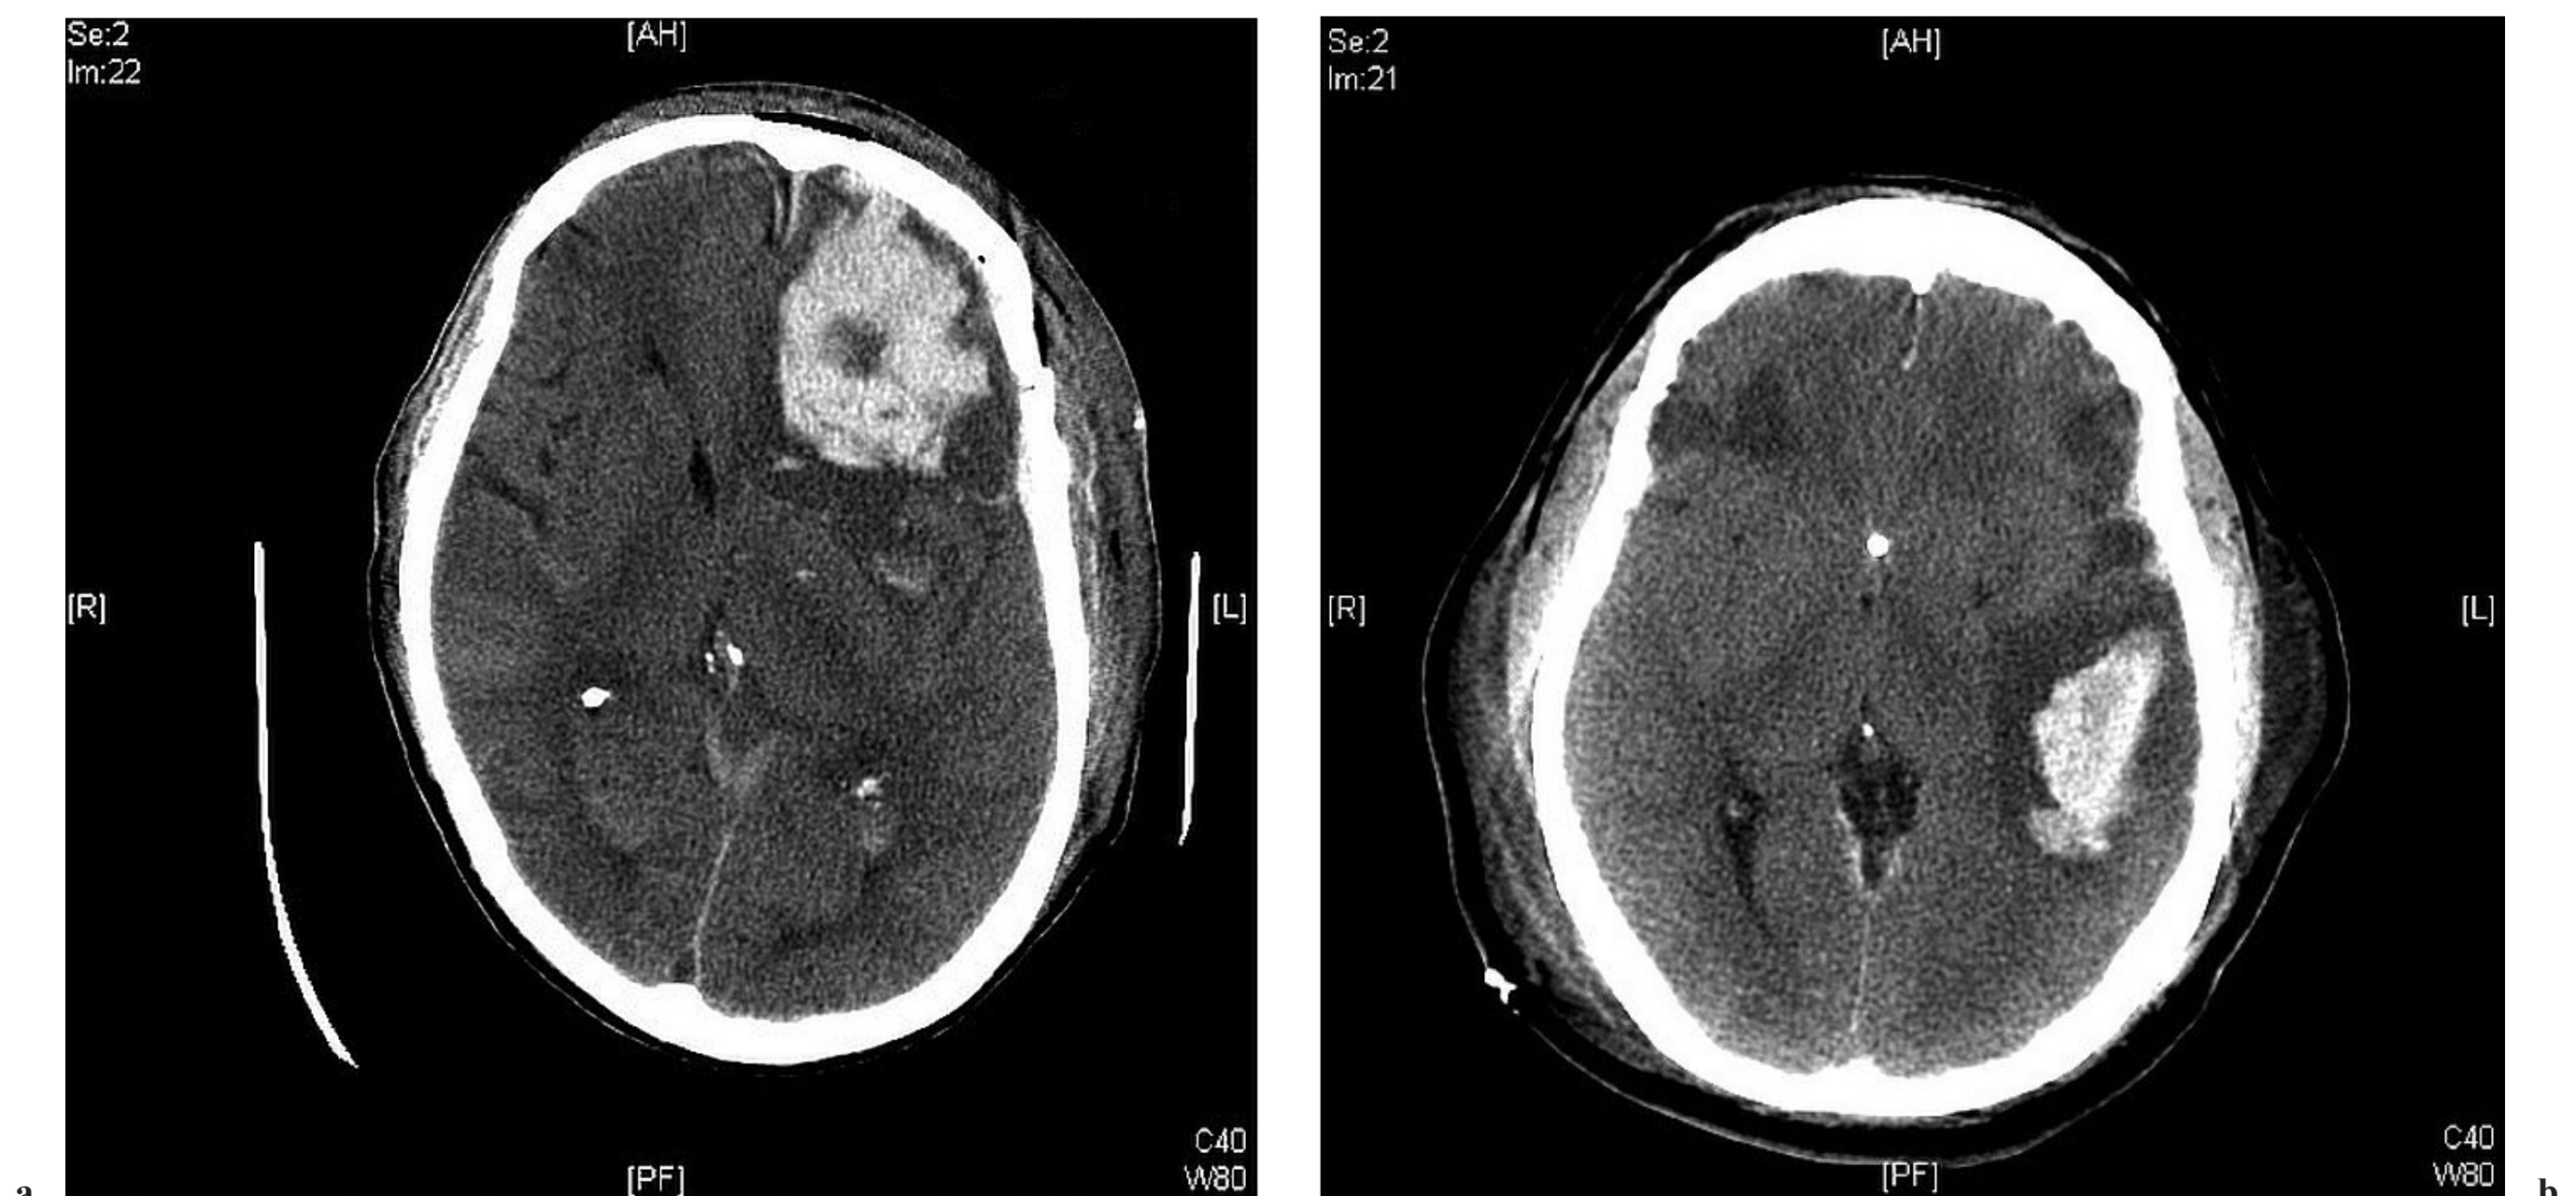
Axial CT images demonstrating (a) frontal and (b) temporal lobe cerebral contusions.
